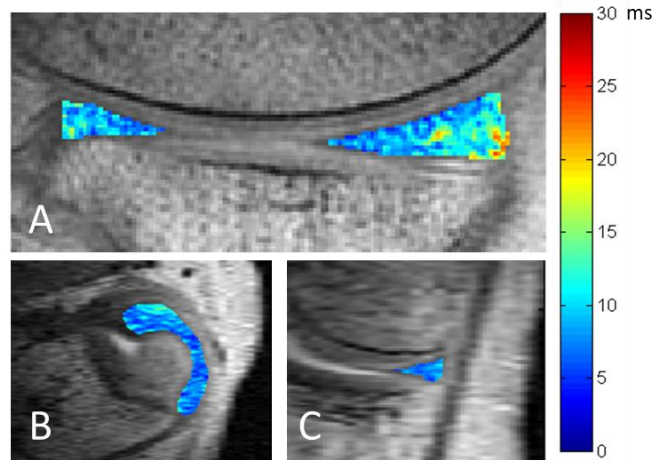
MRI Image of a Knee in the Sagittal Plane [64]
